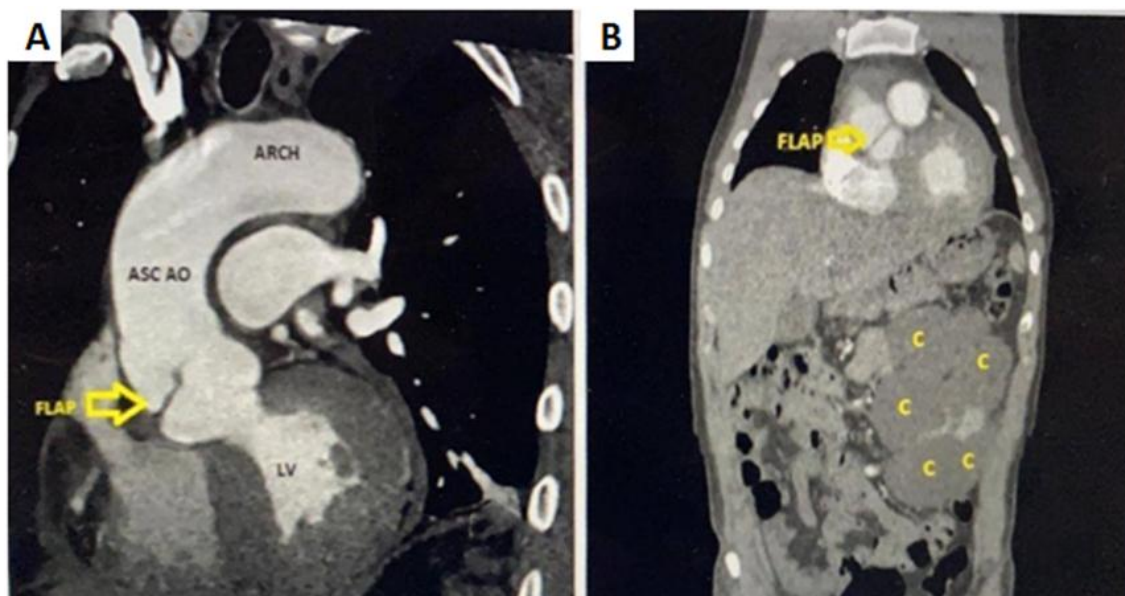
Computed tomography angiography. A: Coronal and B: Sagittal views show a localized dissection flap at the aortic root (open yellow arrow) and multiple cysts in the right kidney (letter C).
